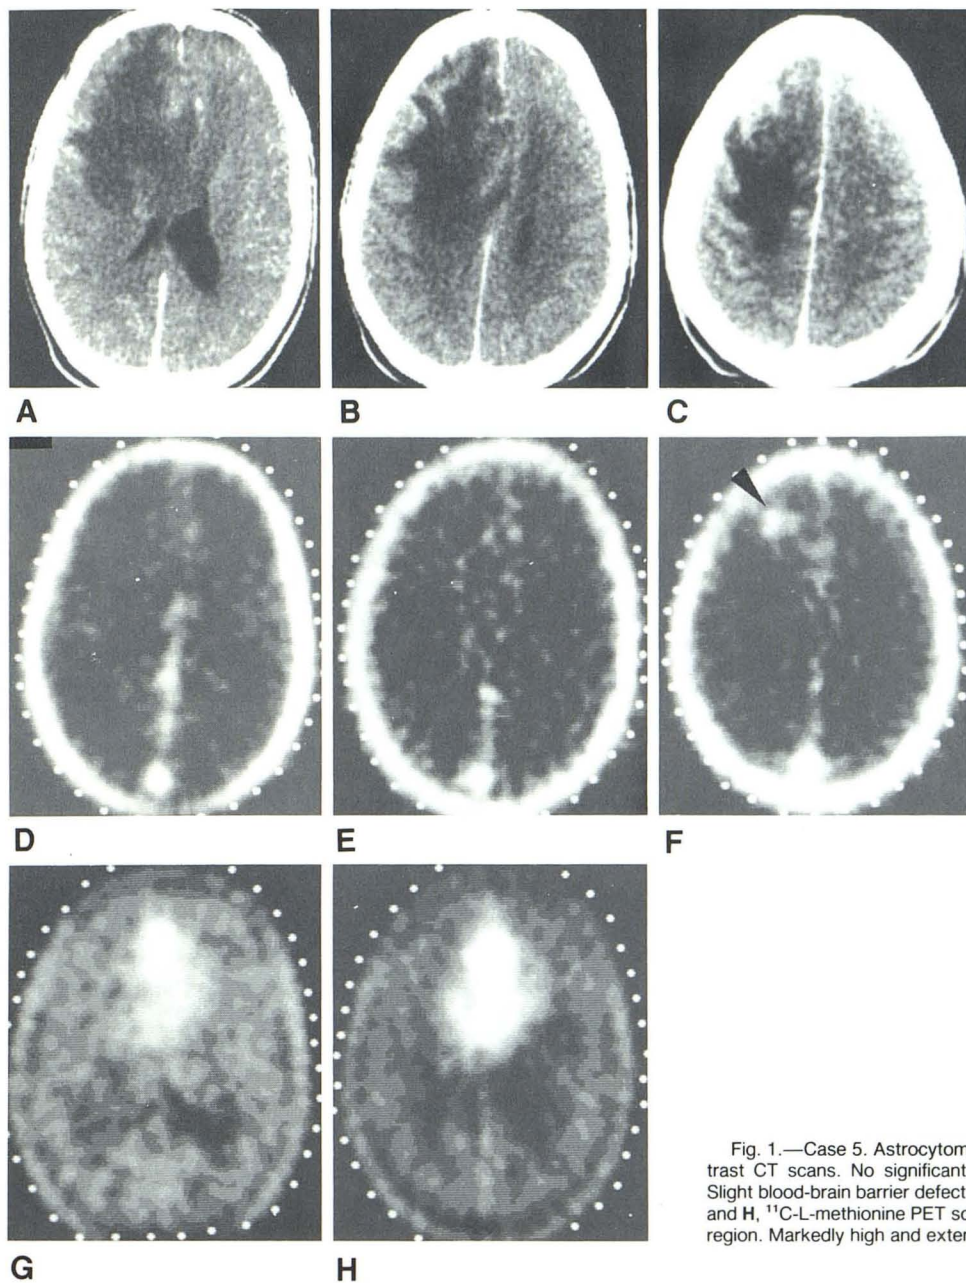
Case 5. Astrocytoma grade III. Initial examinations. A–C, Postcontrast CT scans. No significant enhancement. D–E, ^{68}Ga -EDTA PET scans. Slight blood-brain barrier defect at margin of low-density lesion (arrowhead). G and H, ^{11}C -L-methionine PET scans covering basal two-thirds of supratentorial region. Markedly high and extensive tumor uptake. (Modified from [15].)
